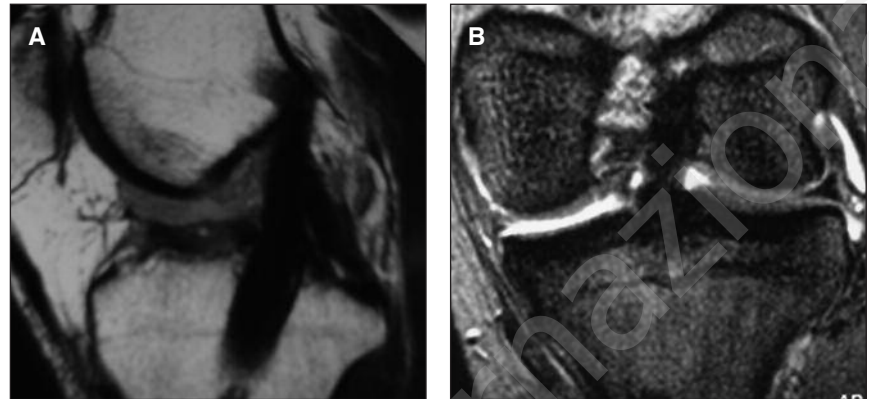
MRI sagittal (A) and coronal (B) views showing a too vertical femoral tunnel.
